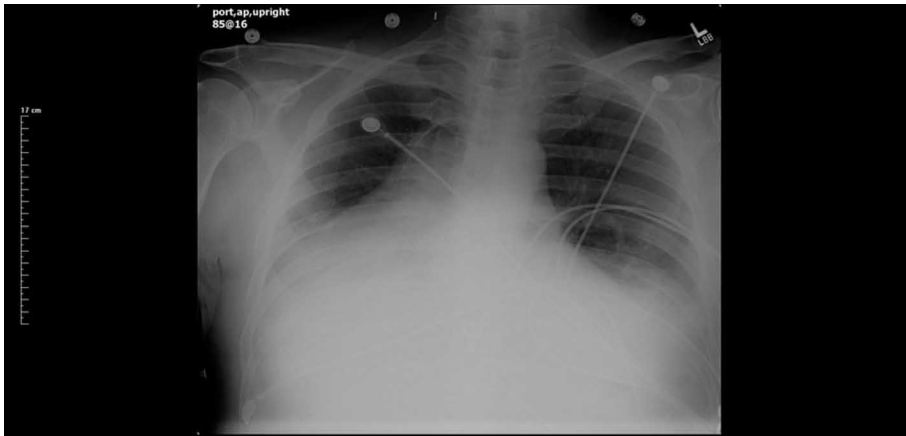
Chest radiograph showing opacity in the right-side hemithorax.
